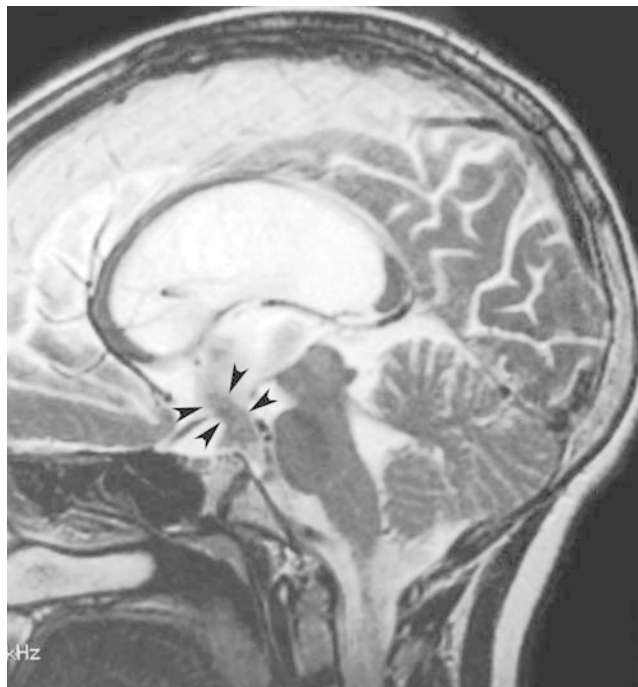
Phase-contrast cine MRI scan demonstrating flow jet through the fenestration (arrowheads).
